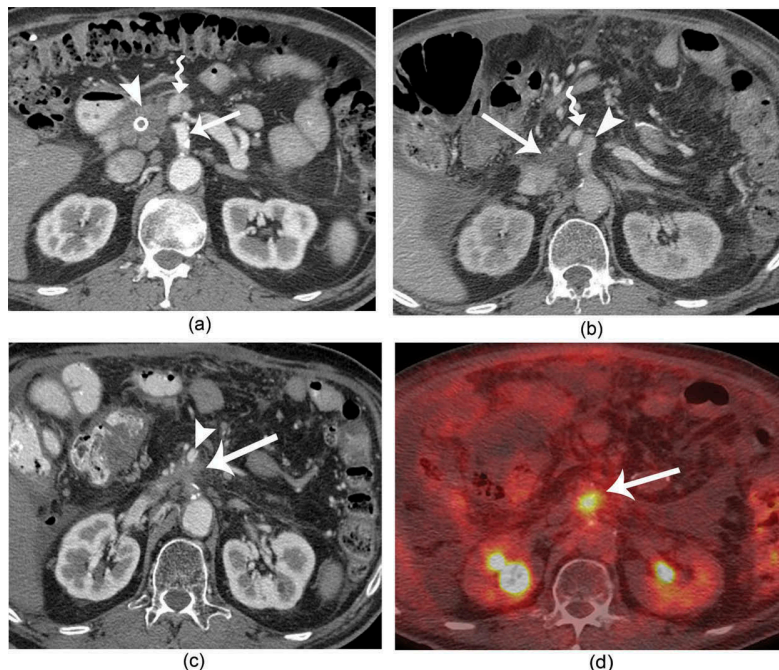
Axial CT and a PET/CT scan in a 70 year old male show (a) a mass in the pancreatic head (arrow) abutting the SMV (squiggly arrow) and is separate from the SMA (arrowhead) as a fat plane is present between the tumor and the SMA. A stent is present in the common bile duct. (b) Fluid is present posterior to the vessels (arrow), an expected finding after surgery. (c) Soft tissue thickening is present posterior to the SMA (arrow). Note the SMV is not seen and obliterated. The soft tissue thickening represents recurrent disease. (d) Axial PET/CT shows FDG uptake (arrow) in the region of the soft tissue thickening suggesting recurrent disease.
